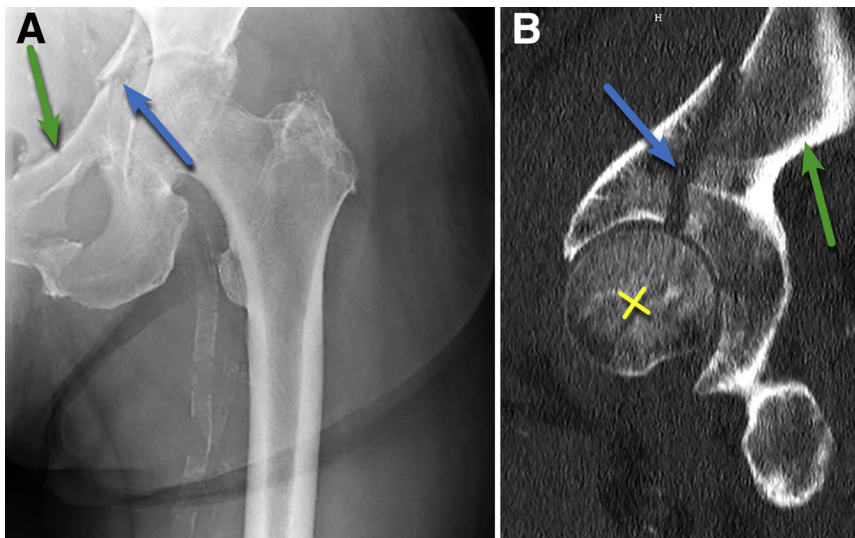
(a) An 81-year-old female patient with an anterior column plus posterior hemitransverse fracture of the acetabulum. Technique: X-ray ap of the left hip. The iliopectineal line (green arrow) is interrupted, which is a sign of an anterior fracture of the acetabulum. The blue arrow marks the fracture line. (b) Digitally reconstructed computed tomography scan of the pelvis in sagittal view, showing a visible split and dislocation of the anterior column (blue arrow). The green arrow marks the posterior column, the x marks the femur head.
